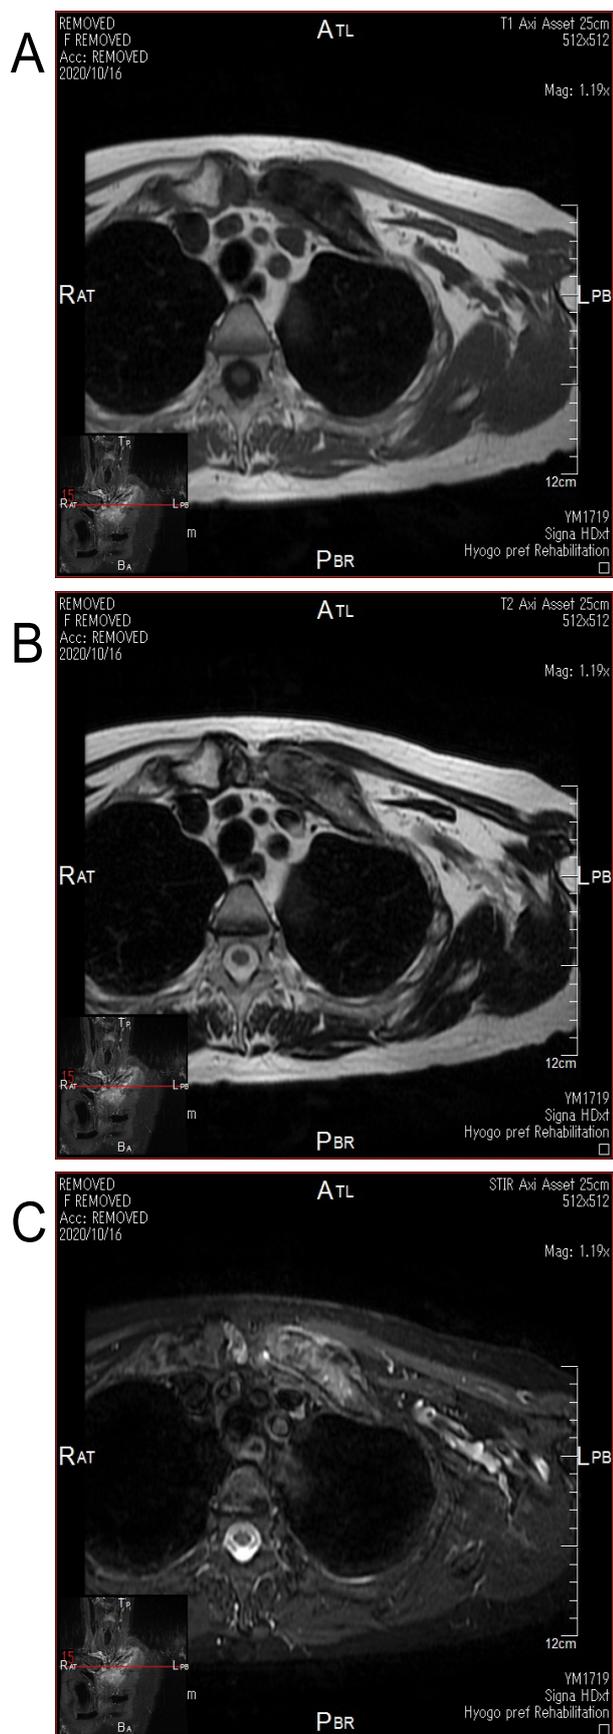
Axial MRI images of the left clavicle revealed sclerotic lesion associated with edematous change in the bone marrow; (a) T1 intensified image, (b) T2 intensified image, and (c) STIR image.
